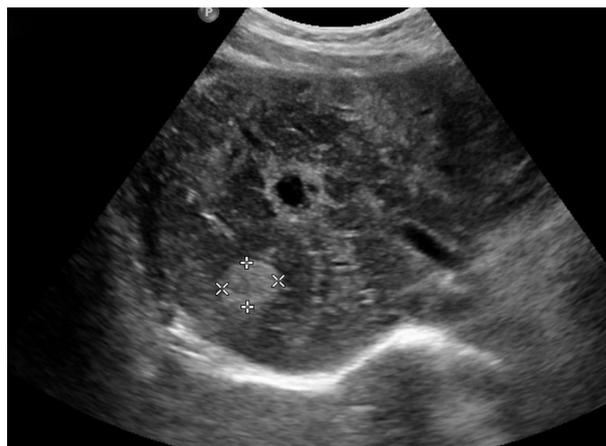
Ultrasound liver showing multiple hypo echoic lesions in liver.
